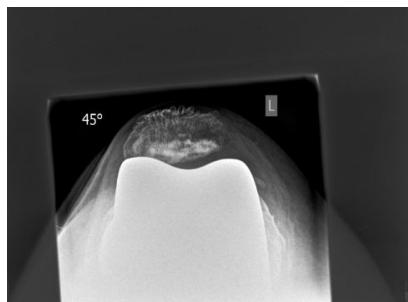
Tangential radiograph of the right knee of a 78-year-old male patient showing a lateral tilt of the patella as a sign of malrotation (internal rotation) of one of both components of the total knee arthroplasty.
